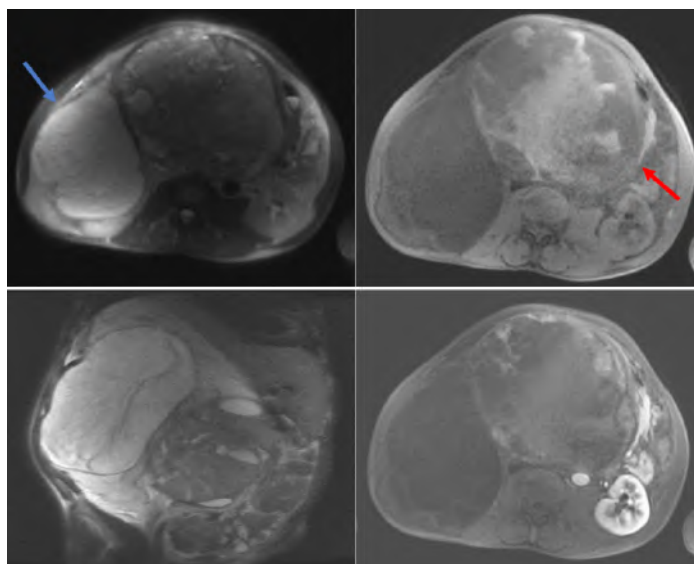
Abdominal MRI demonstrating the presence of a voluminous tumour with fleshy (red arrow), cystic components (2, blue arrow) pushing back the abdominal structures (kidneys, intestines, pancreas and liver).
